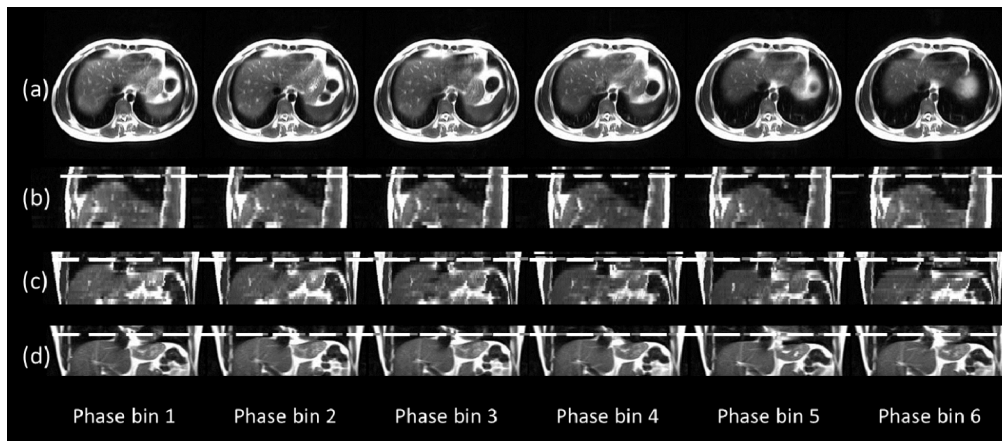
Reconstructed 4D-MRI for one representative healthy volunteer in axial view (a), sagittal view (b), coronal view (c), and in comparison with T2-weighted cine in coronal view (d).
